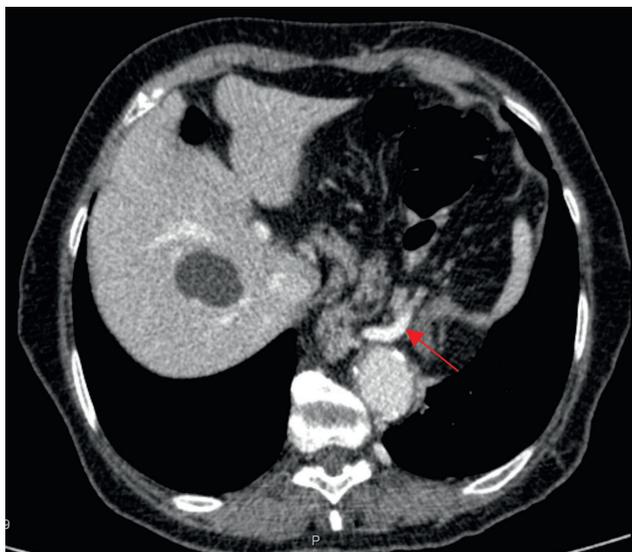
CT scan showing pancreatic tissue and splenic vein deviation through the diaphragm (red arrow) – axial view.
